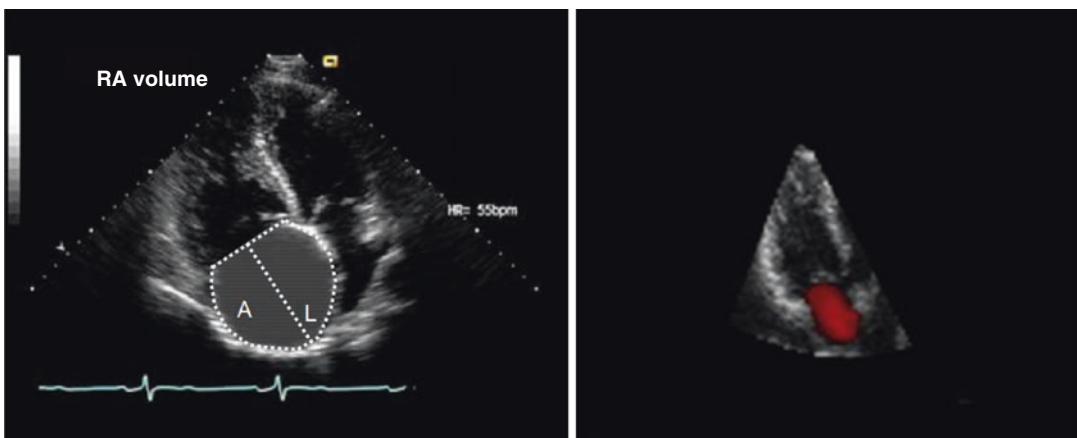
Right atrial volume index assessment: on the left, two dimensional echocardiographic assessment where A is the right atrial area and L is the length of right
